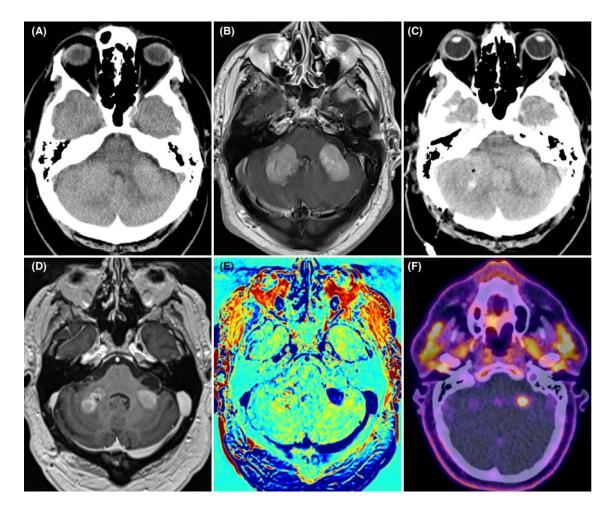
The efficacy of two novel applications of (i) contrast clearance analysis (CCA) and (ii) FCH PET-CT to differentiate viable lymphoma from post-surgical biopsy benign change in central nervous system lymphoma (an unmet clinical need).
